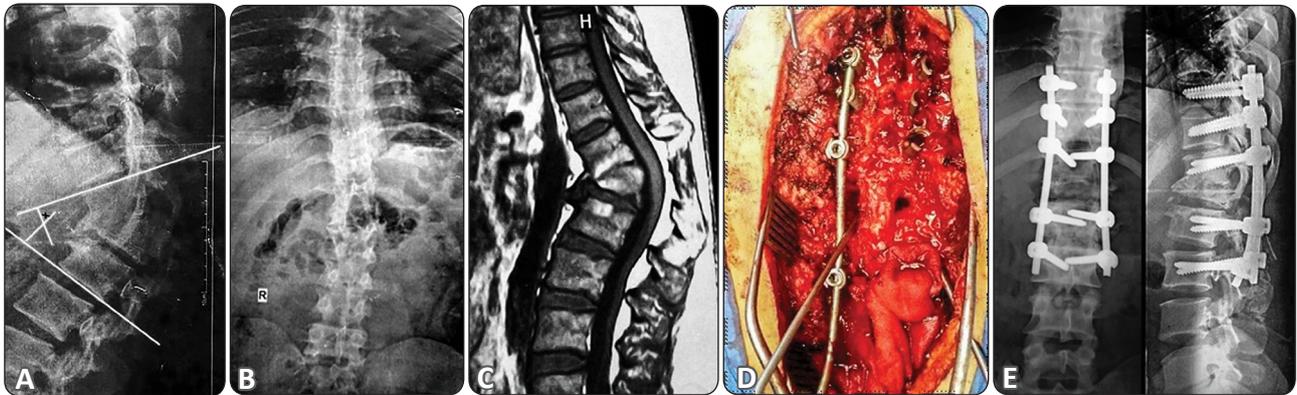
(A) X-ray thoracolumbar spine lateral view showing old L1 fracture complicating with post-traumatic kyphotic deformity of 55 degree. (B) X-ray thoracolumbar spine A-P view showing preserved coronal balance. (C) MRI thoracolumbar spine sagittal T1 WI showing post traumatic kyphotic deformity of the thoracolumbar junction with preserved CSF signals behind the apex of the deformity indicating long standing deformity development. (D) All posterior approach exposure shows pedicle screws inserted 3 levels above and 2 levels below the target level, temporary rod to the left, suction is in osteotomy cavity. (E,F) X-ray thoracolumbar spine AP, lateral views showing postoperative stabilization of the thoracolumbar spine with postoperative kyphotic angle of 10°.
